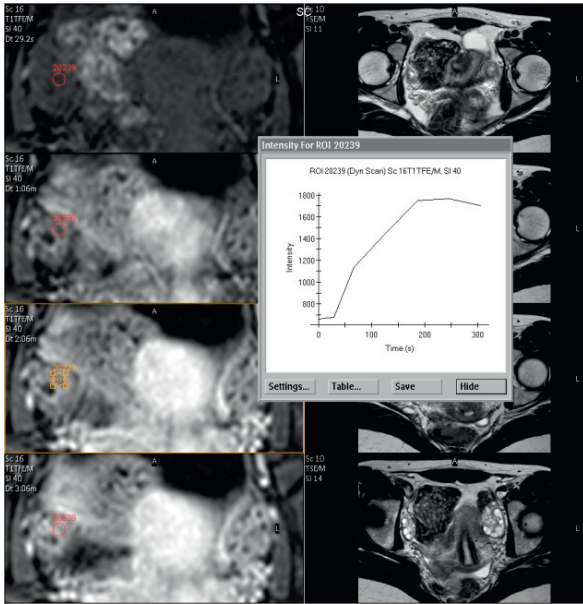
Dynamic T1-weighted fat-suppressed GE sequences before and during intravenous injection of Gadolinium-based contrast medium. Signal intensity is assessed by placing a region of interest in the ovarian stroma. The workstation’s software can present the increase and steady-state/decline of signal intensity graphically as shown.
